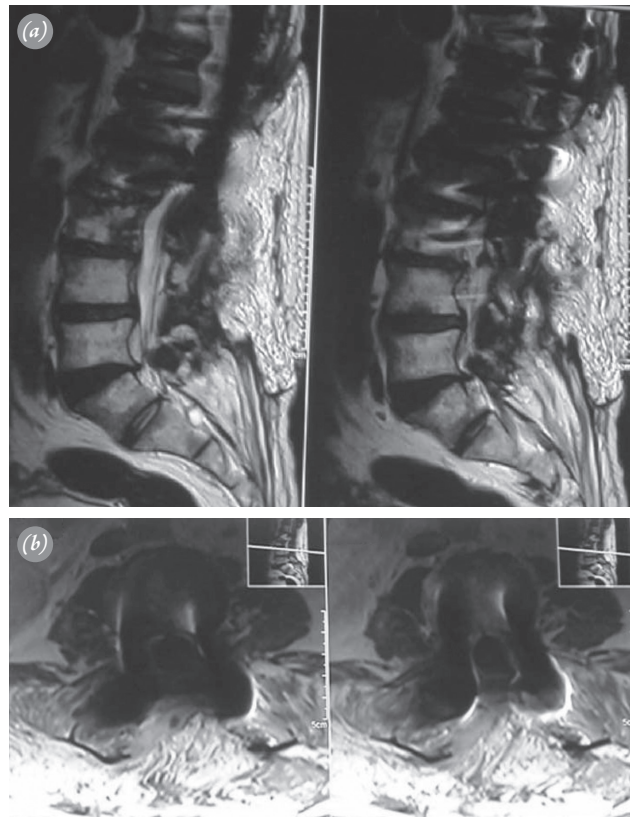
(a, b) There is no pseudomeningocele formation, which was confirmed by MRI at last follow-up.
